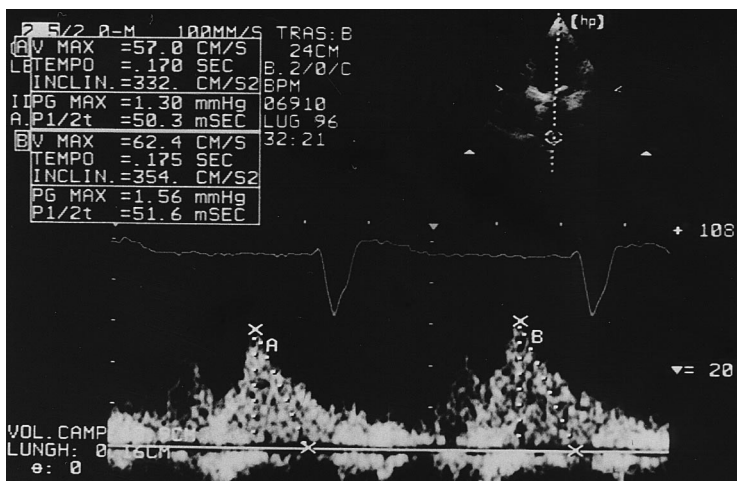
Transthoracic pulsed wave Doppler recording in a patient with chronic AF and dilated cardiomyopathy (MPWP was 24 mm Hg). The deceleration time of the diastolic flow (see the value indicated as "tempo") (calculated as the time interval between peak diastolic velocity and the upper deceleration slope extrapolated to the zero baseline) showed little variation (170 to 175 ms) over two consecutive beats (A and B).
